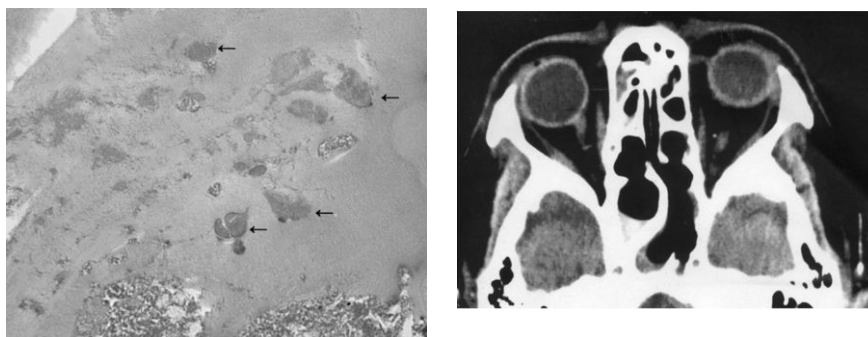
A plain computed tomography (CT) at 4 weeks after operation revealed the disappearing soft tissue density of the left ethmoid sinus wound in comparison with the preoperative CT (see Figure 1).
